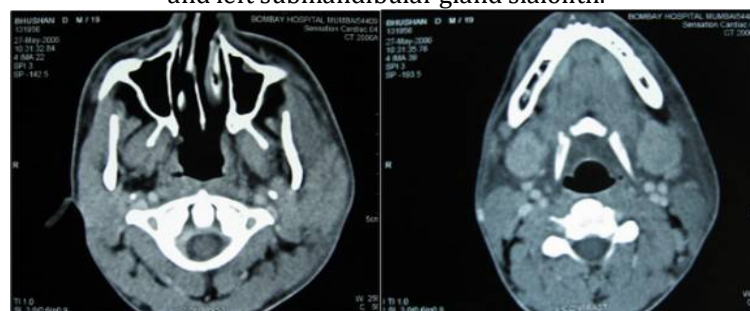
(a) axial section of CT scan show enlargement of right parotid gland with compression of subcutaneous fat. (b)axial section of CT scan show enlargement of submandibular lymph node.
